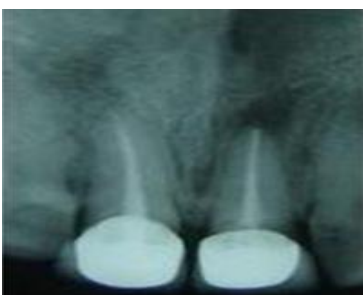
Radiograph showing fracture at cemento-enamel junction
